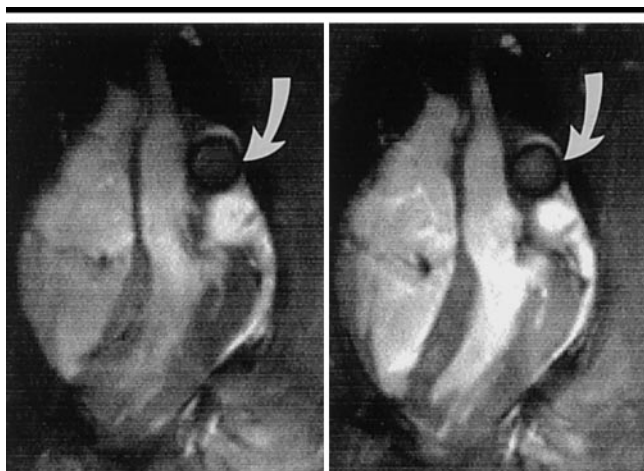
VEC MR magnitude image (25/7; flip angle, 30°; section thickness, 5 mm) acquired through midportion of nitinol stent (arrow) in pulmonary position during midsystole before (left) and 20 minutes after (right) administration of 0.05 mmol iron per kilogram blood-pool MR imaging contrast medium NC100150. Contrast medium enhanced SNR in cardiac chambers, ascending aorta, and pulmonary vasculature and to a lesser extent in stent lumen.
